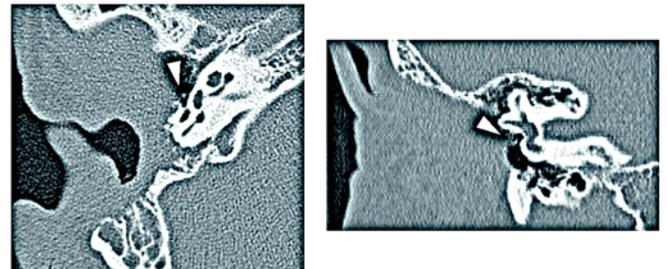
Results of computed tomography in (a)–(f) six subjects. Triangles indicate connection of fibrotic tissue to ossicles.
